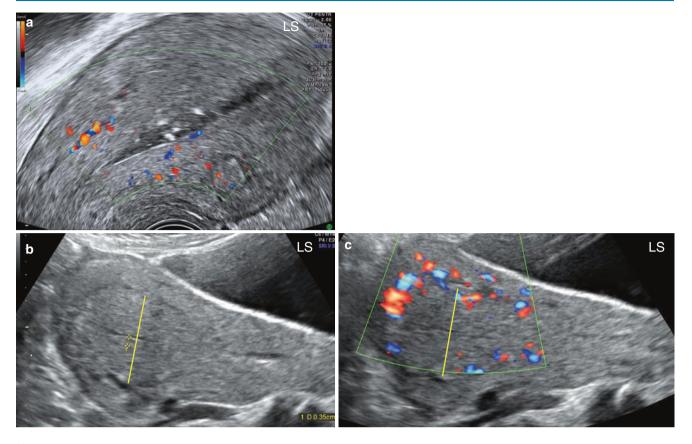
Normal post-partum endometrium. (a) Post-partum second week – fluid, debris and minimal gas shadows seen in the endometrial cavity. Single-layer thickness of the endometrium was 4.4 mm. (b, c) Uterus – on post-partum Day 18 with (b) single-layer endometrial thickness of 3.5 mm. This can be wrongly interpreted as being much thicker (*marked in the image*) because of isoechoic endometrium and prominent arcuate vessels wrongly interpreted as the EMJ. (c) Arcuate vessels seen on Doppler
